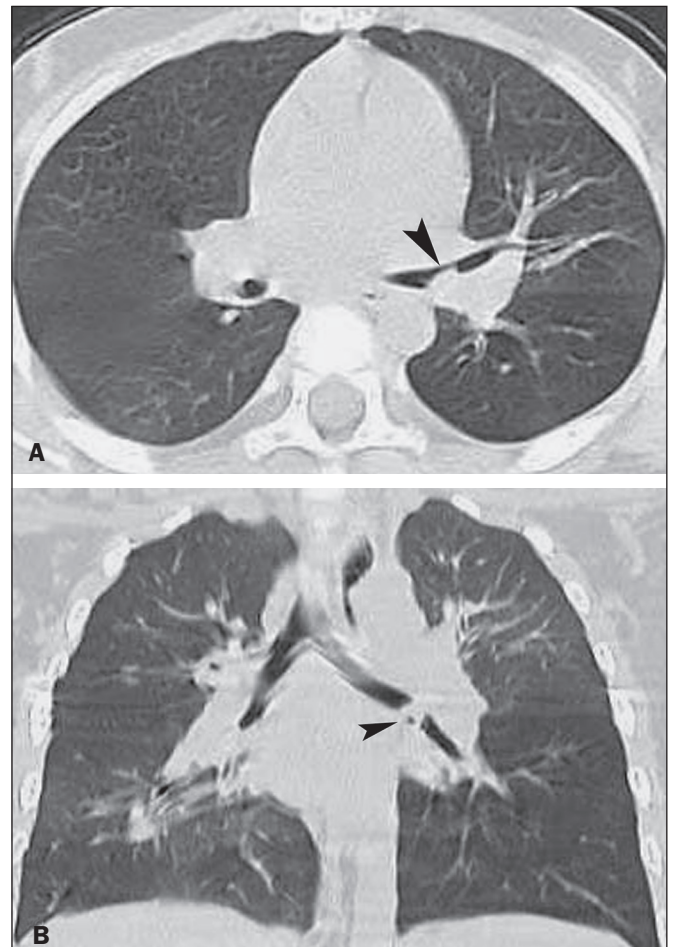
A 23-year-old man who presented with bronchospasm because of an aspirated roasted peanut. A: Axial CT image of the chest (lung window) showing partial obstruction of left main bronchus (arrowhead) due to the retained object. B: Coronal reformatted CT image showing near-total obstruction of the left main bronchus due to the impacted FB (arrowhead).
